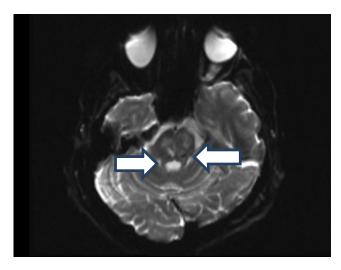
DWI MRI – Pontine ischemic stroke
